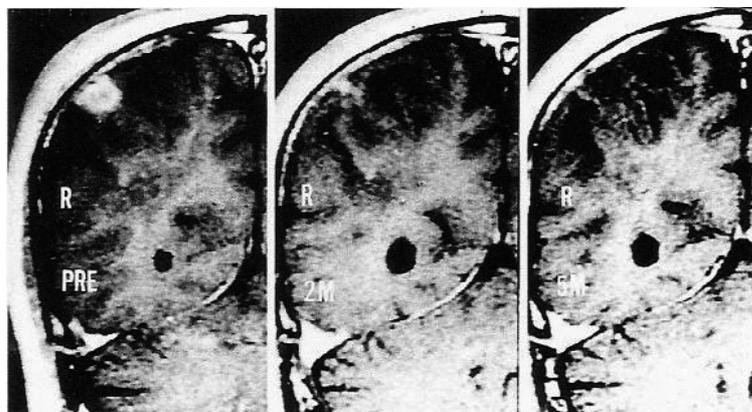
Image analysis of patients with brain cancer treated with pritimumab [33]. Malignant astrocytoma of the right parietal lobe before (a), and after (b,c) pritimumab therapy. (a), Gadolinium-enhanced magnetic resonance image shows a small tumor of the right parietal lobe. The same tumor at 2 months (b) and at 5 months (c) after pritimumab therapy. Gd-enhanced MR images show that the tumor lesion decreased in size and finally disappeared.
